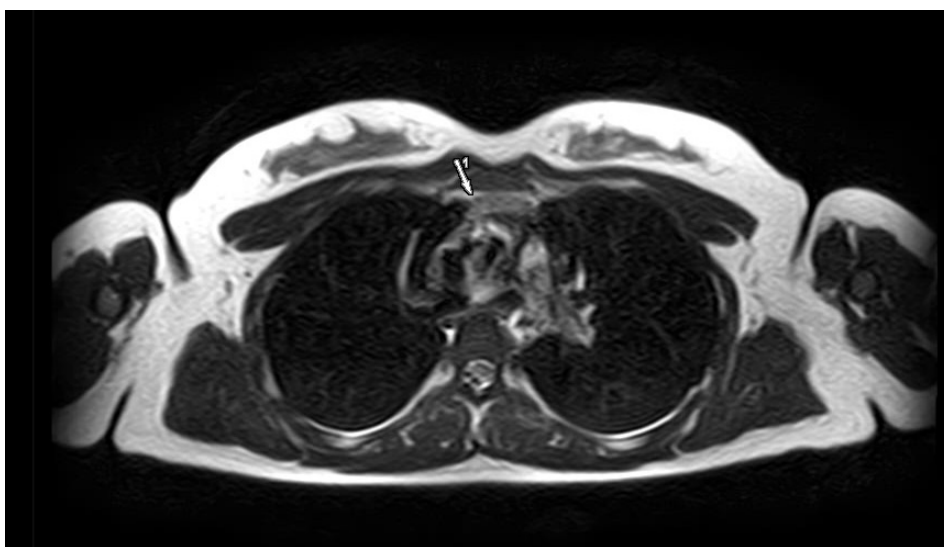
Chest magnetic resonance imaging demonstrating abnormal formation in the anterior mediastinum (arrow).
